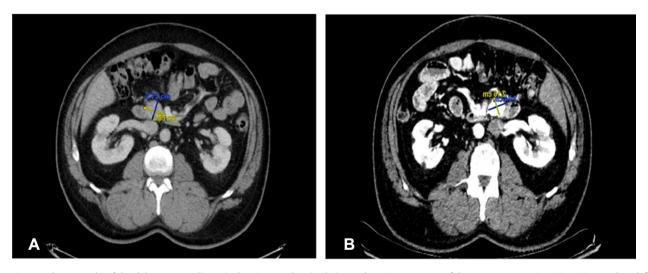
A*, Computed tomography of the abdomen upon diagnosis showing an enhancing lesion at the uncinate process of the pancreas measuring 3.5×2.5 cm and no definitive intraabdominal metastatic lesions. *B*, Computed tomography of the abdomen 2 months after the radiofrequency ablation therapy showing an interval decrease in the size of the previously described enhanced uncinate process mass and measuring 2.9×2.6 cm. No evidence of new lesions or distance metastasis.
